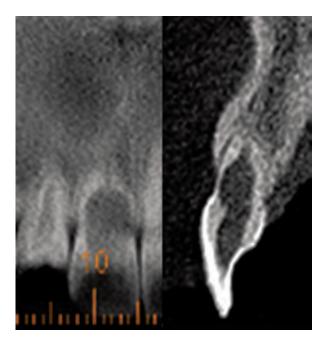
Cone beam computed tomography of the affected tooth demonstrating an extension of the internal resorption in the frontal and sagittal planes.
